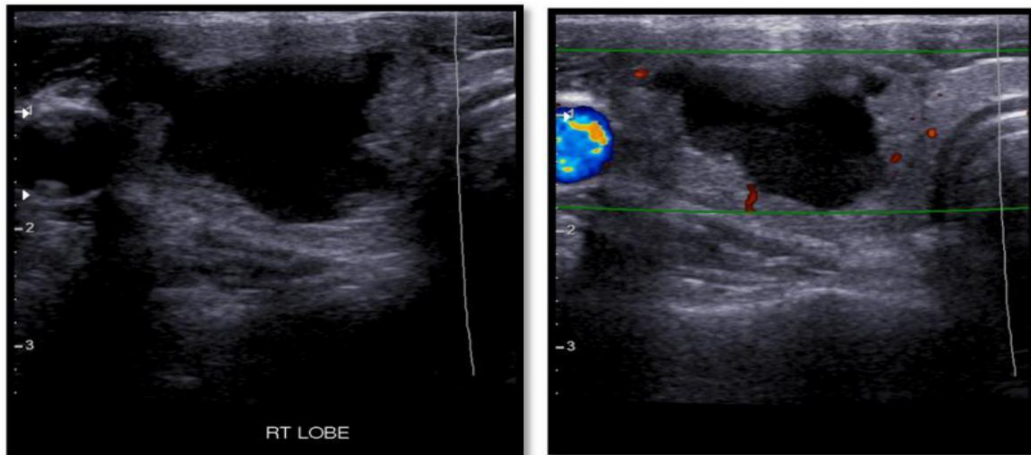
HRS Ultrasound of right lobe of thyroid showing colloid nodule with cystic degeneration and peripheral vascularity.
